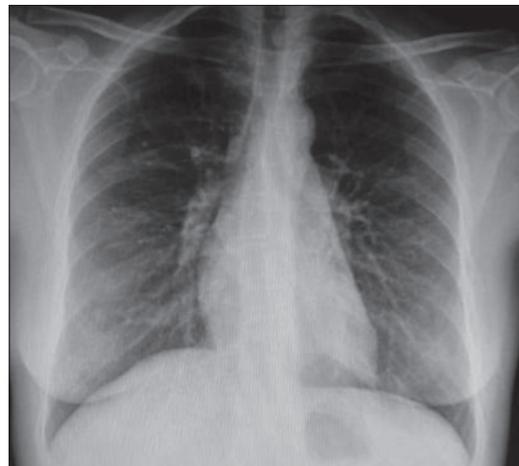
Chest X-ray of the same patient before discharge
